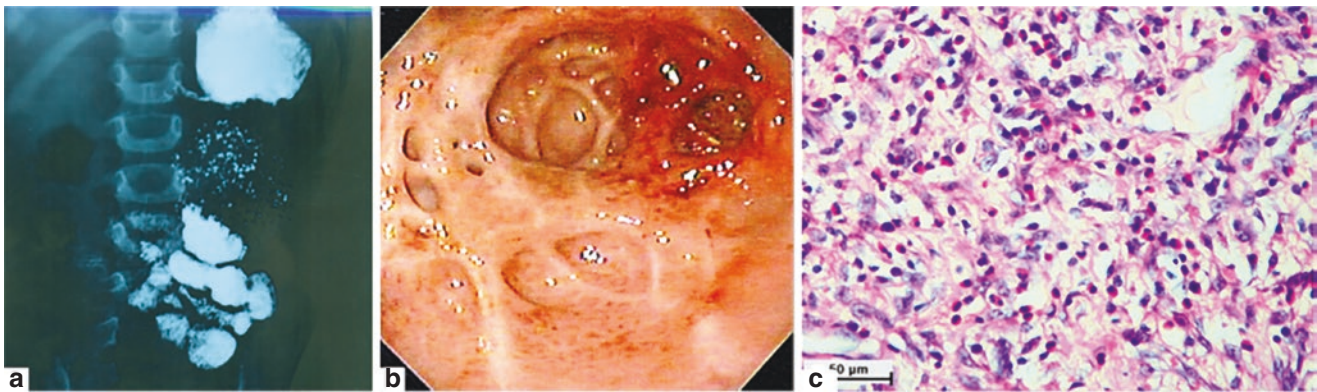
(a–c) Gastric outlet obstruction on a 3-year-old girl with eosinophilic gastritis. (a) Barium meal X-ray showing absence of the duodenal bulb and the C-loop. Note that the distal stomach is also not visible. (b) Endoscopic visualization of the gastric mucosa showing
